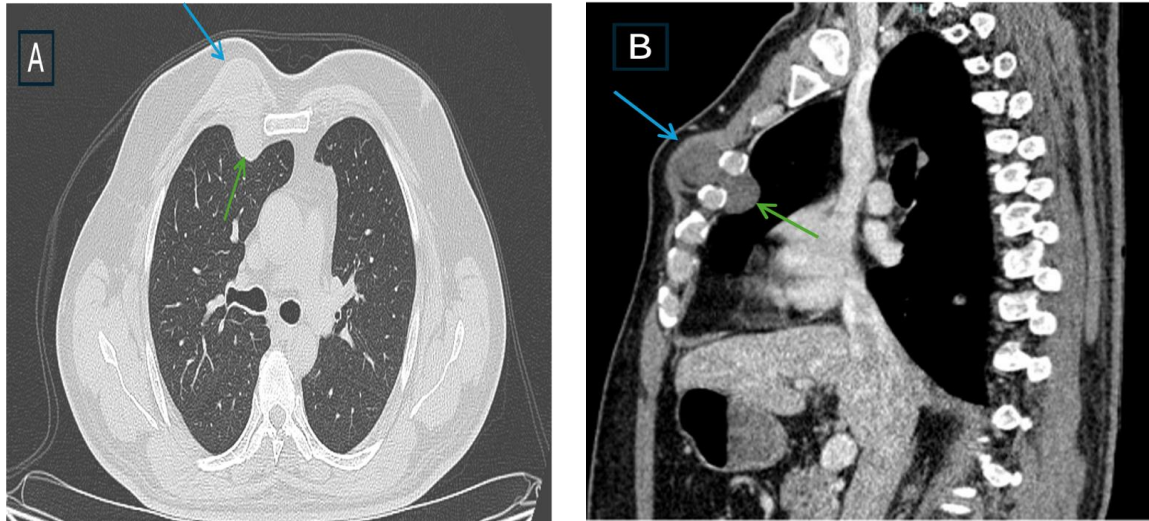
Cross and Sagittal sections on a CT scan showed a well-defined lesion in the anterior chest wall with extrathoracic (blue arrow) and intrathoracic (green arrow) extension between 3rd and 4th ICS.
